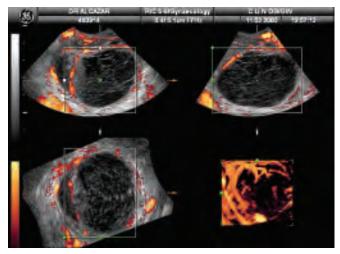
Three-dimensional power Doppler depiction of the vascular network from a benign ovarian cystic tumor
